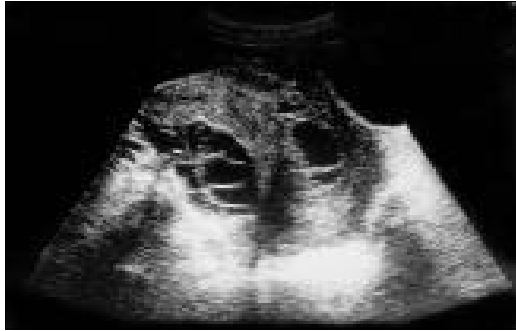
Pelvic ultrasound displays multiple cysts at both adnexae and uterus.
